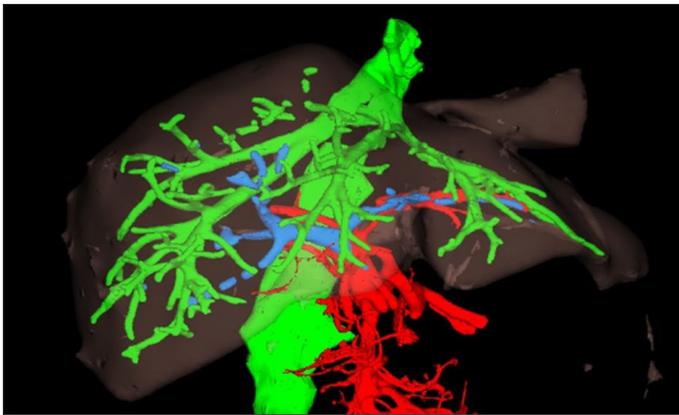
Drafting of the 3D prototype by coloring the vascular structures in an angiographic computed tomography section (colors were changed before 3D printing).
